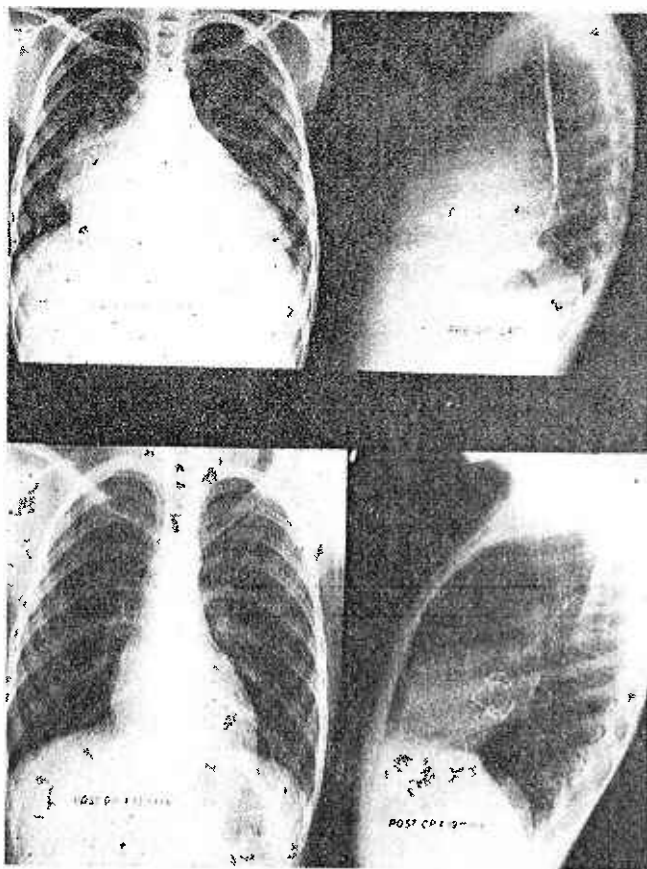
A typical pre-and post-operative X-Ray of the chest before and after homograft valve replacement.
